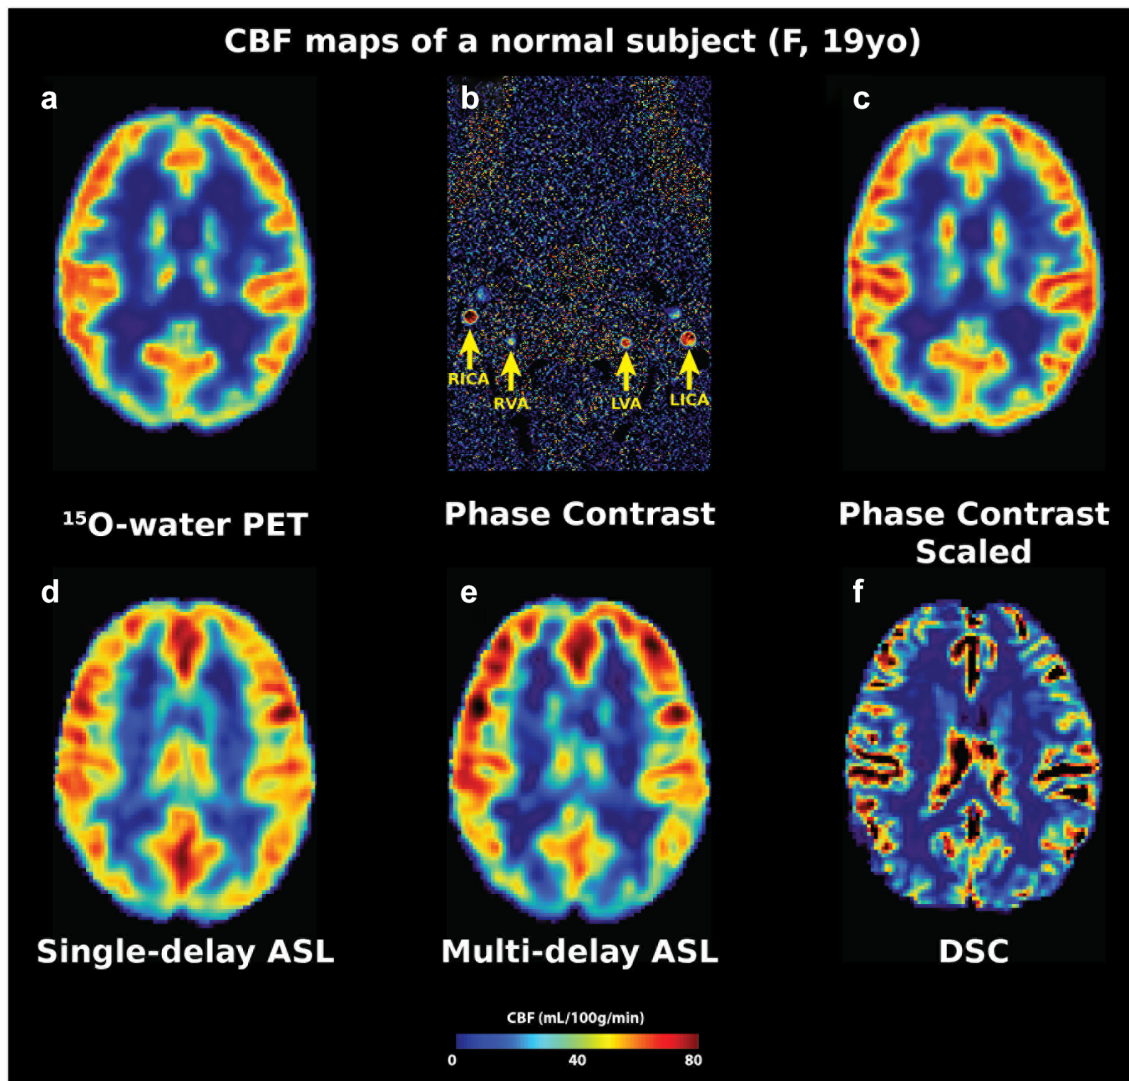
CBF maps of a normal subject (female, 19 years old). (a) CBF measured by ^{15}O -water PET; (b) phase contrast map showing right internal carotid artery (RICA), right vertebral artery (RVA), left vertebral artery (LVA), and left internal carotid artery (LICA). The flow volume in these vessels is used to compute CBF; (c) CBF map measured using the flow volume values; (d) CBF map measured by single-delay ASL; (e) CBF map measured by multi-delay ASL (five PLDs); (f) CBF measured by DSC MRI.
